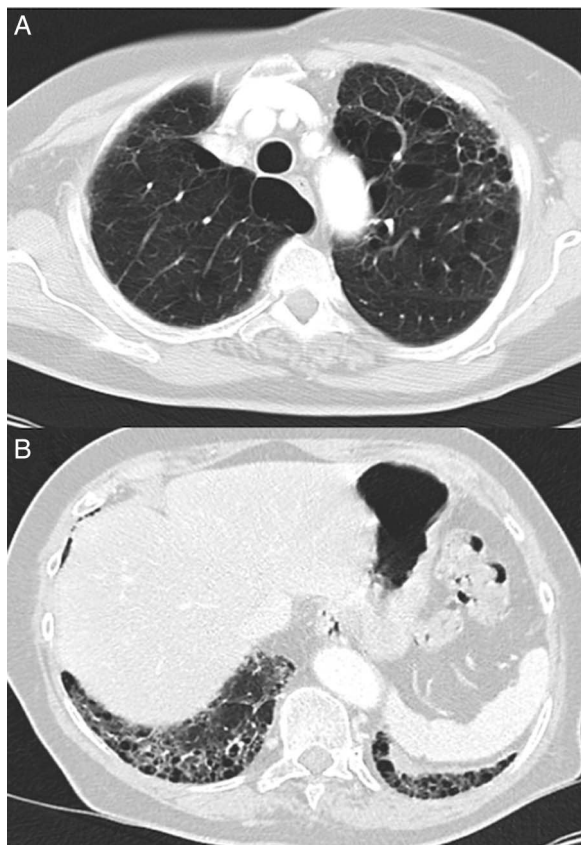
Axial high-resolution CT showing association between emphysema in the upper lobes (A) and fibrosis in the lower lobes (B).
